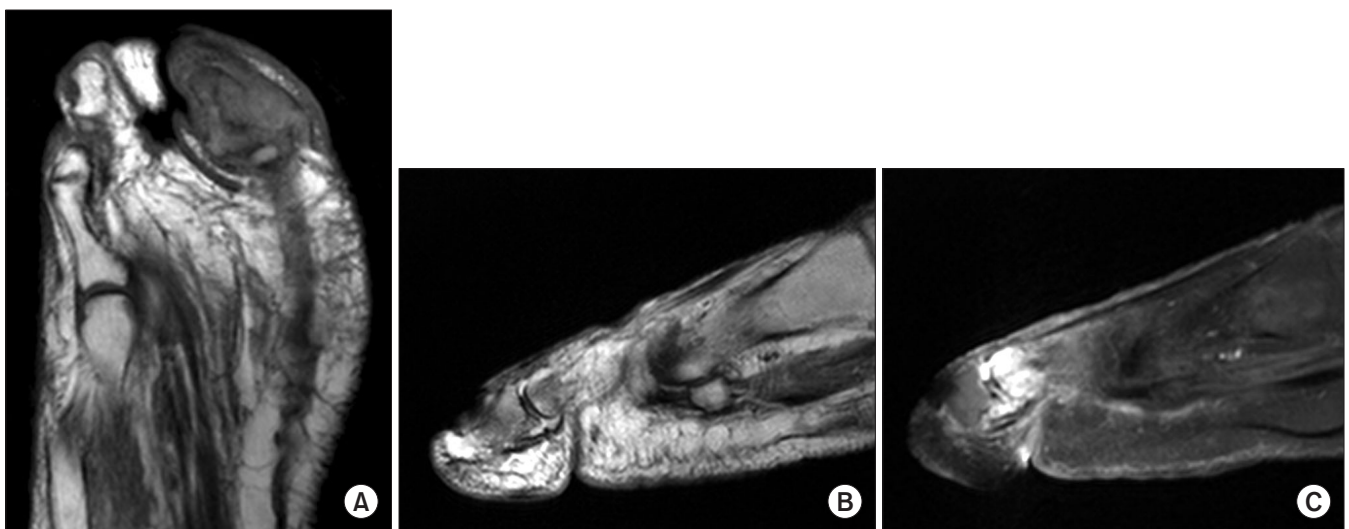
Preoperative magnetic resonance imaging findings. (A) A coronal T1-weighted image reveals an irregularly contoured nodular lesion at the distal phalanx. This lesion involves the great toe's distal phalanx with bony erosion and the adjacent flexor tendon. (B) A sagittal T2-weighted image reveals low signal intensity at the proximal and distal phalanx. (C) An enhanced T1-weighted image reveals low signal intensity at the great toe's proximal phalanx, synovial thickening with enhancement, and a small amount of joint effusion at the interphalangeal joint.
